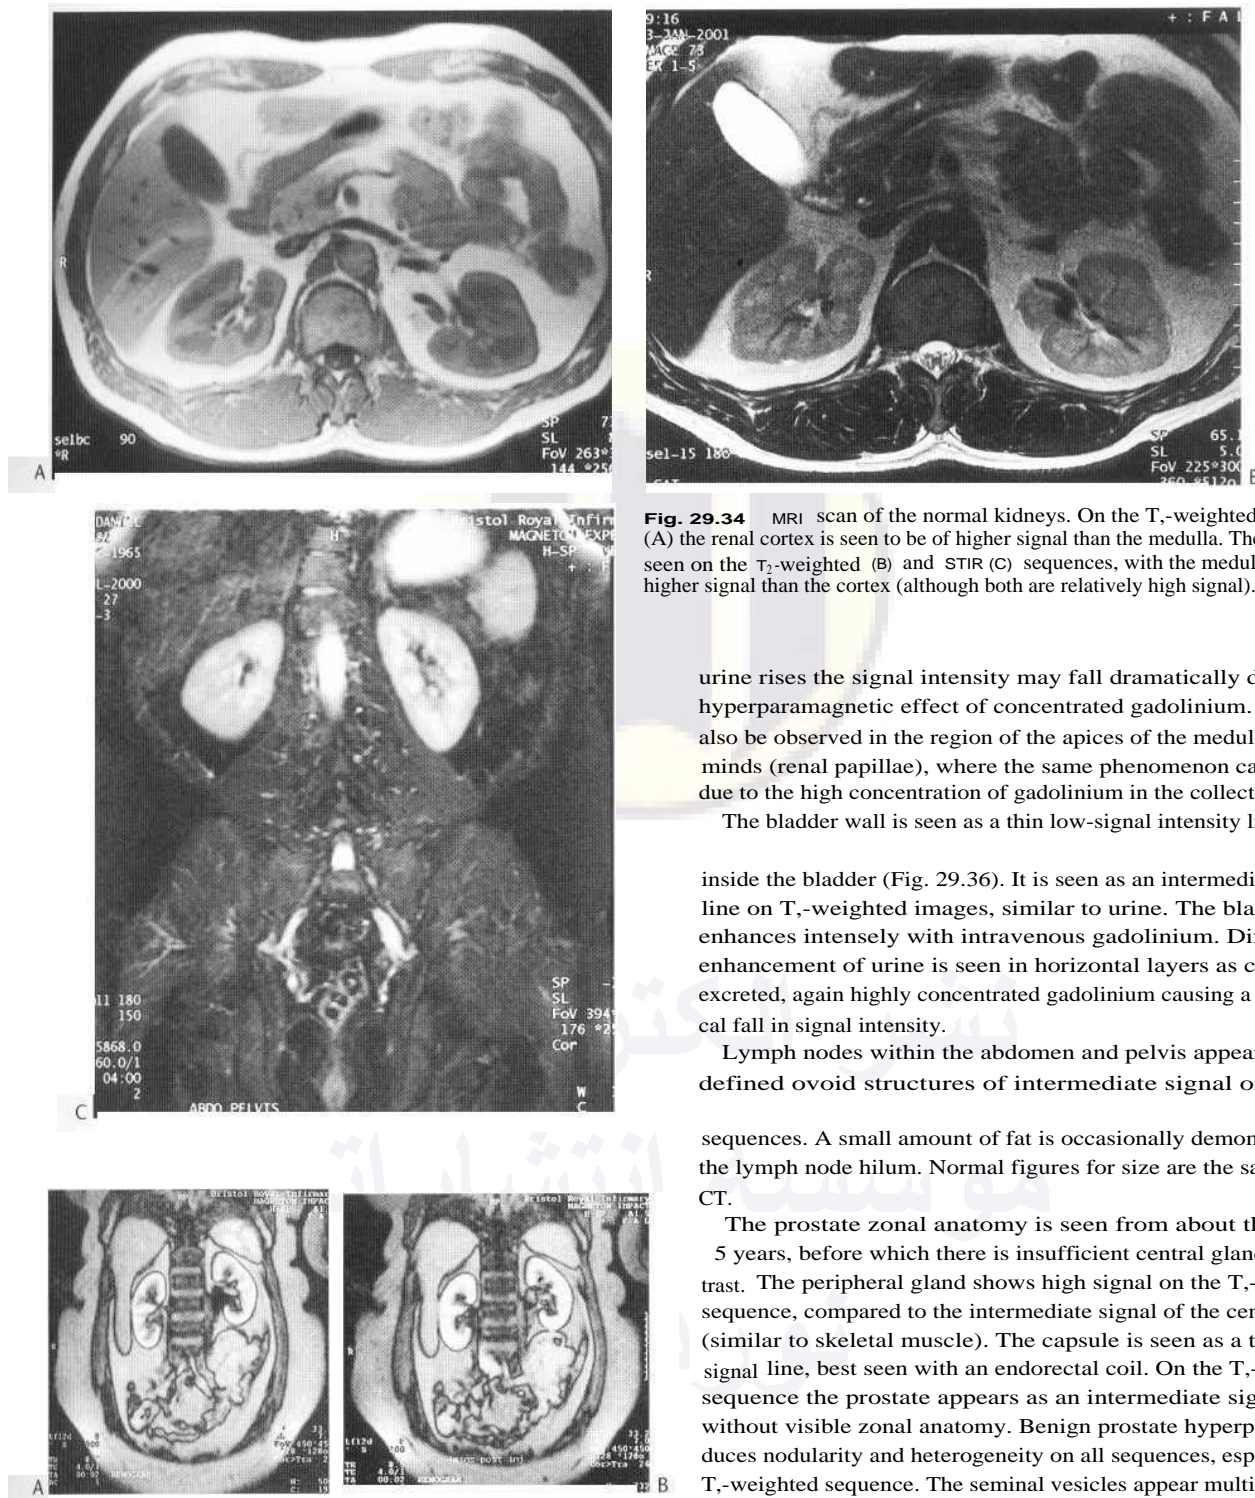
MRI scan of the normal kidneys. On the T_1 -weighted sequence (A) the renal cortex is seen to be of higher signal than the medulla. The reverse is seen on the T_2 -weighted (B) and STIR (C) sequences, with the medulla being of higher signal than the cortex (although both are relatively high signal).
